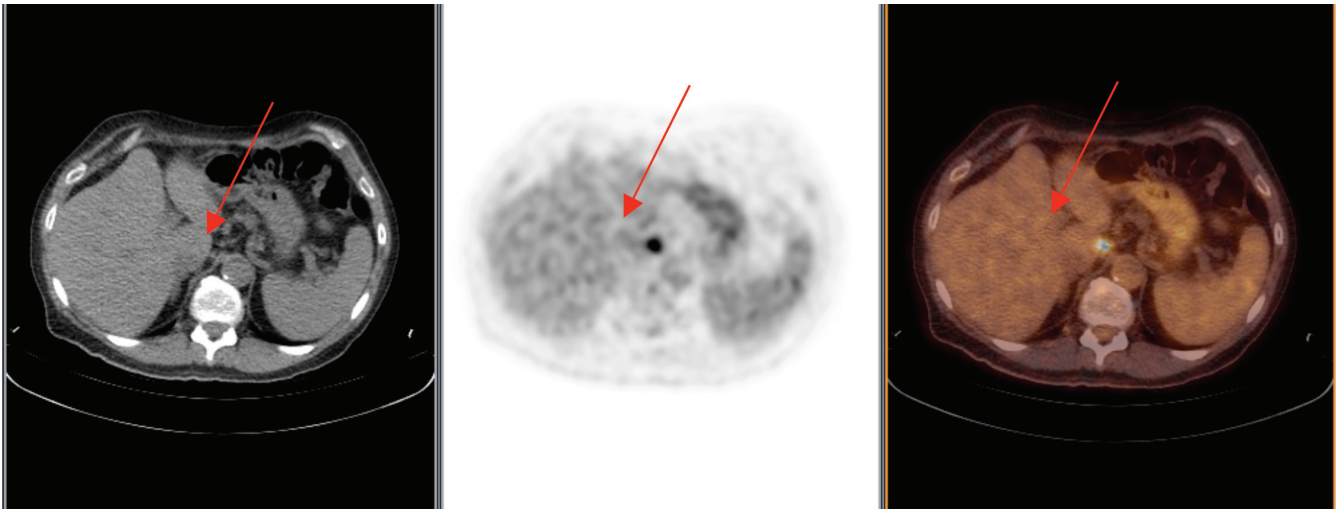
The presence of the 3-mm node (arrows) metastases on the PET/CT scan showed a highly suspicious abdominal node. A subsequent biopsy confirmed nodal metastases. The 3-mm abdominal metastases, which were missed on CT, changed staging and management in this case.
